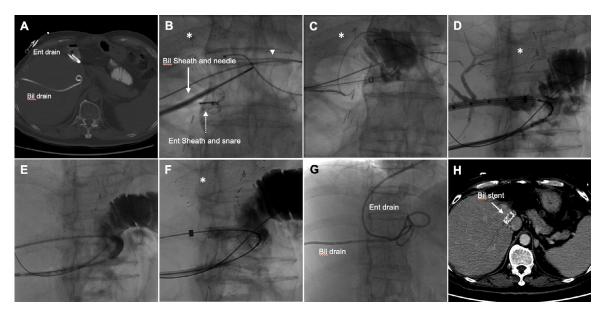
A noncontrast CT of the abdomen (A) shows an external biliary drain and an enteric drain in place. Two sheaths were placed through the biliary (solid white arrow) and enteric (dashed white arrow) accesses (B). A safety wire was placed next to the enteric sheath in a tandem fashion (arrowhead, B). A neo-biliary-enteric tract was created using a Rosch-Uchida access needle via the biliary sheath (B) and a wire advanced into the bowel (C). A snare was used to capture the trans-biliary wire (C) to establish a through and through access (D). The biliary-enteric tract was dilated using 6×60 mm balloon (E) and a 10×60 mm biliary stent was placed (F). An internal-external biliary catheter was placed through the internal biliary stent (G). A follow up CT 3 years after procedure (H) demonstrated appropriate positioning of the biliary stent (partially visualized) without biliary ductal dilation. Star shows a stent in the right hepatic vein (B-F). Bil = biliary; Ent = enteric.
